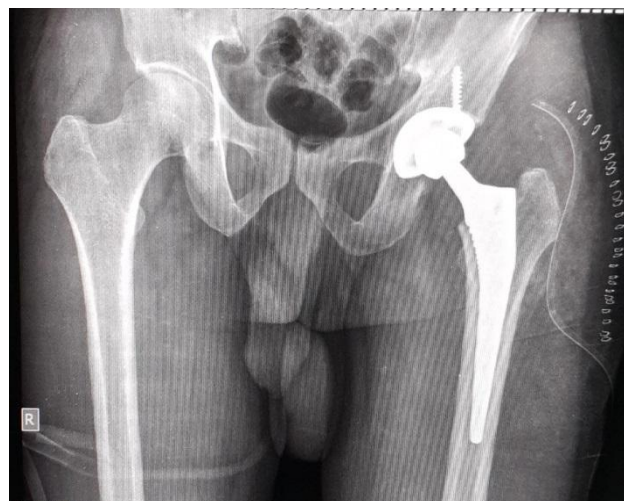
Plain X-ray radiograph- Pelvis with both hips Antero-Posterior view taken after surgery showing the Total Hip Replacement implant in situ
